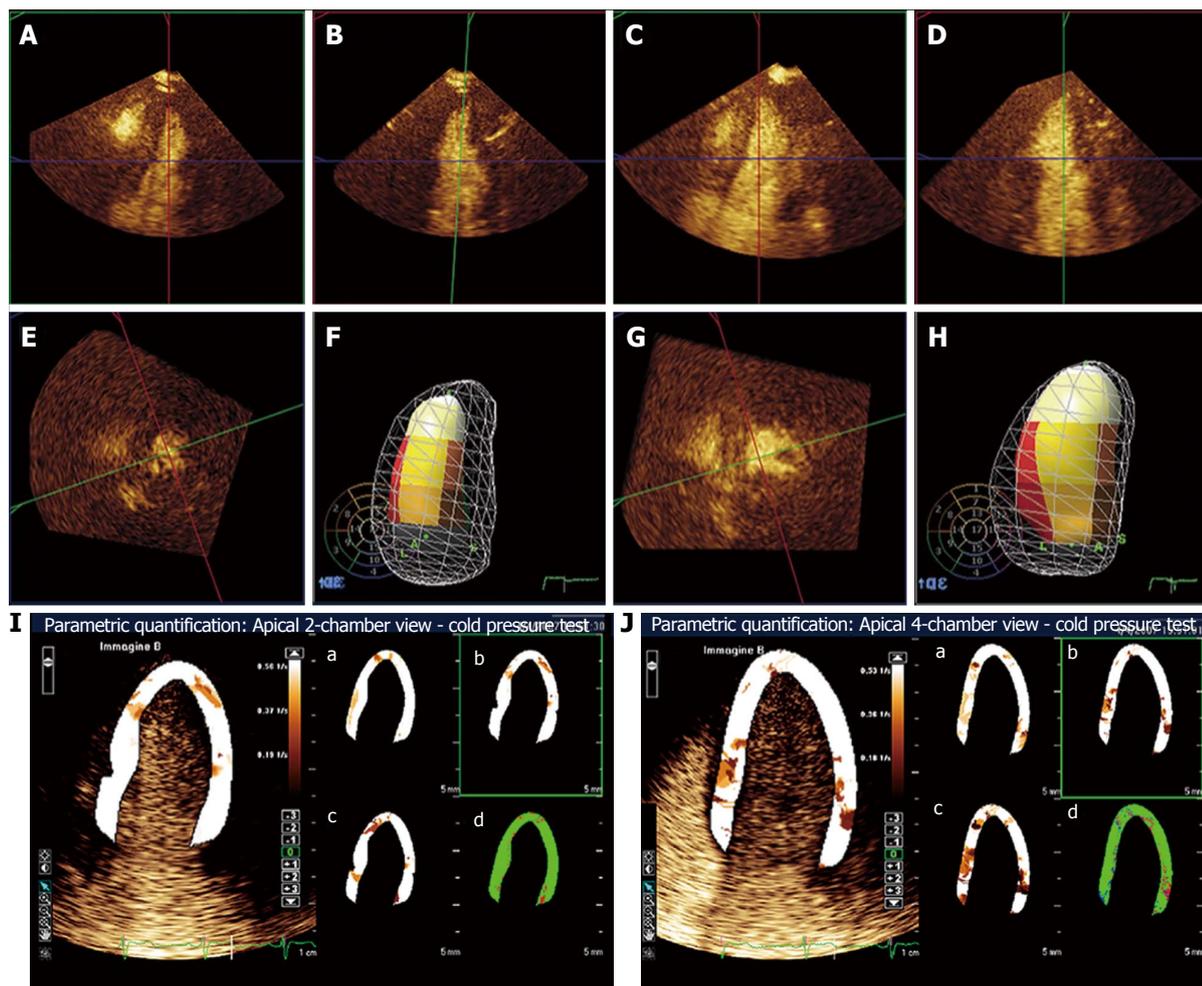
Real-time 3-dimensional myocardial contrast echocardiography during follow-up using cold pressor test in a patient who recovered from apical ballooning syndrome. A, B and E: Reconstructed 4-chamber (A), 2-chamber (B) and short-axis (E) end-systolic frames at baseline; F: 3-dimensional systolic volume rendering as left ventricular cast inside the diastolic mesh volume rendering. The American Society of Echocardiography 17-segment model of the left ventricle is reproduced as a bulls-eye in the background, and superimposed color-coded onto the left ventricular cast; C, D and G: Reconstructed 4-chamber (C), 2-chamber (D) and short-axis (G) end-systolic frames using the cold pressor test; H: The diastolic and systolic 3-dimensional casts as in panel 1d. Note that wall motion is normal at baseline, whereas apical akinesia develops during the cold pressor test; I and J: Apical 2-chamber and 4-chamber, respectively, parametric myocardial contrast echocardiography quantification using the cold pressor test; the slope β of the replenishment curve is superimposed onto the left ventricular wall in 2-chamber and 4-chamber views, respectively. Perfusion parameters A , β and $A \times \beta$ are superimposed onto the same left ventricular wall as in panels I and J, respectively, in panels a, b and c; panels d represents the goodness of fit. Parametric images demonstrate homogeneous perfusion during the cold pressor test. The coronary flow reserve in this patient was 1.10 (normal range 2.77 ± 0.70).
